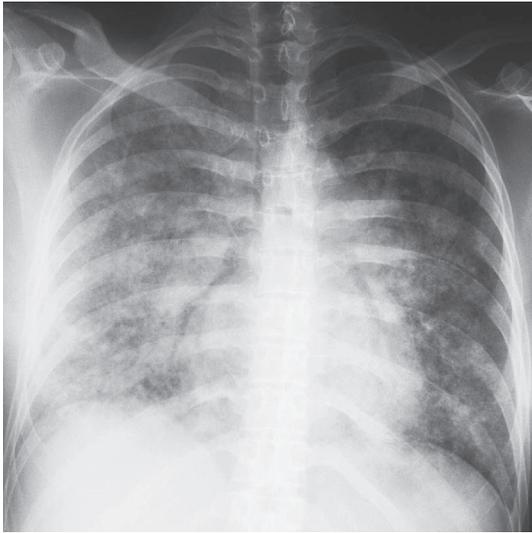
Chest radiograph obtained at admission. Diffuse consolidations and ground-glass opacities in both lungs were observed.
